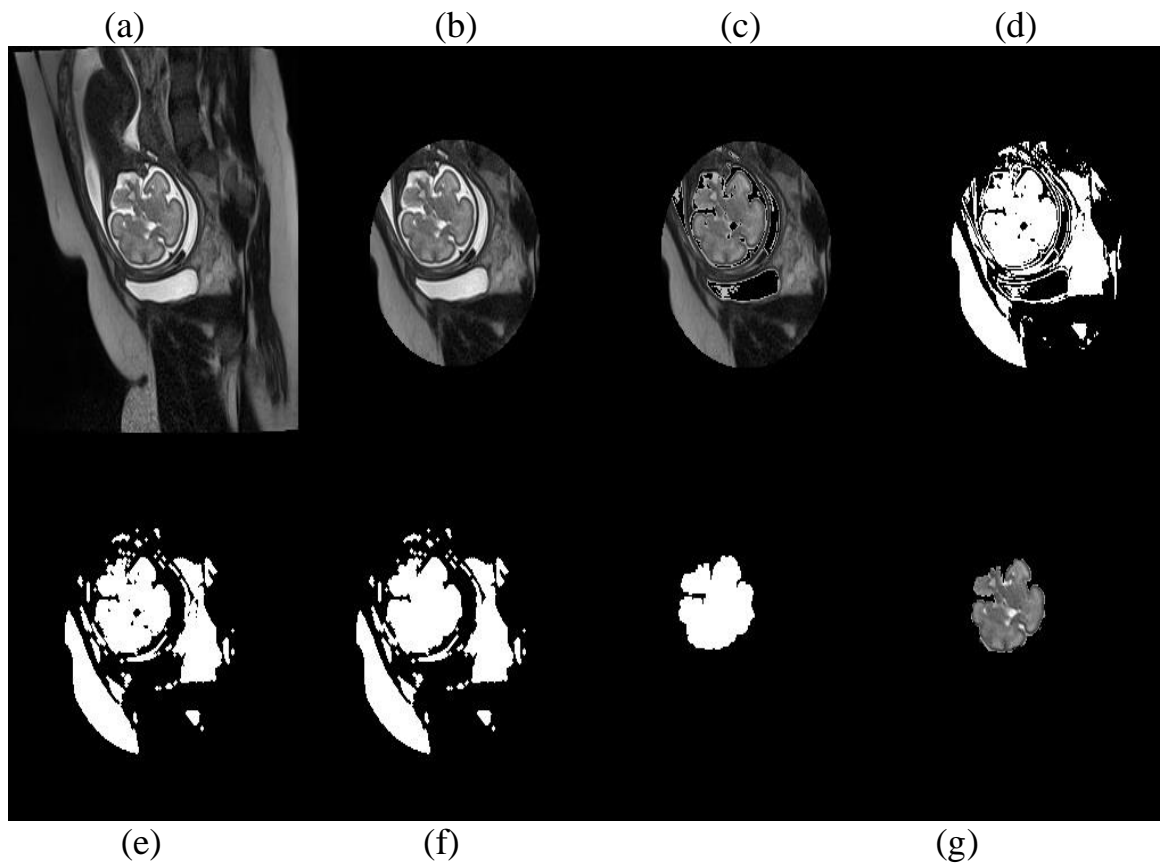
(a) Original MRI scan (b) region of interest (c) after removing high intensity pixels in ROI (d) I_b (binary image) (e) morphological opening result (f) hole filled operation result ((g) segmented fetal brain
